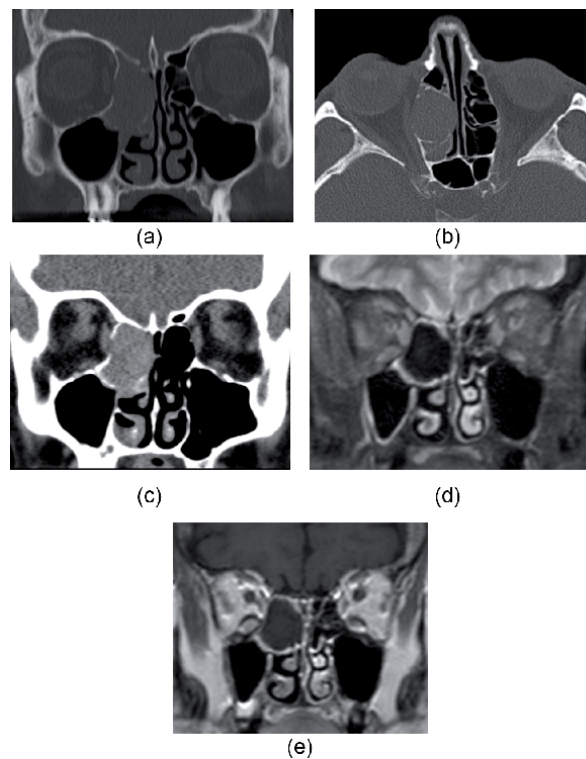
(a) Coronal CT and (b) axial CT with bone algorithm and (b) with soft tissue algorithm demonstrate a pyocele (superinfected mucocele). (c) Coronal CT with soft tissue algorithm shows high attenuation more characteristic for a pyocele than a mucocele. (d) Coronal MRI T2 with fat suppression shows characteristic signal void of the pyocele. (e) Coronal MRI T1 with gadolinium shows contrast medium enhancement only in the peripheral mucosal lining.
